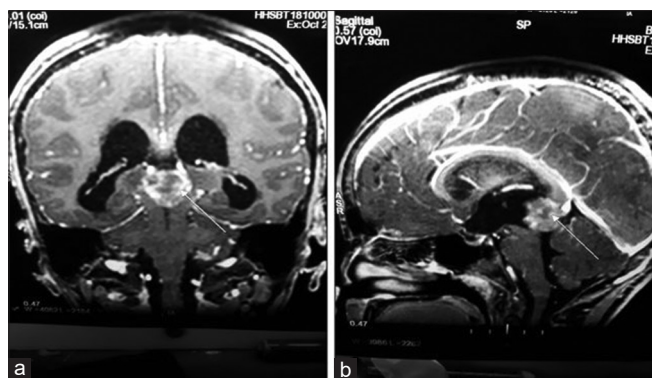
Magnetic resonance imaging brain T1 weighted postcontrast images in coronal (a) and sagittal (b) planes showing a heterogeneously enhancing mass in the region of pineal gland
